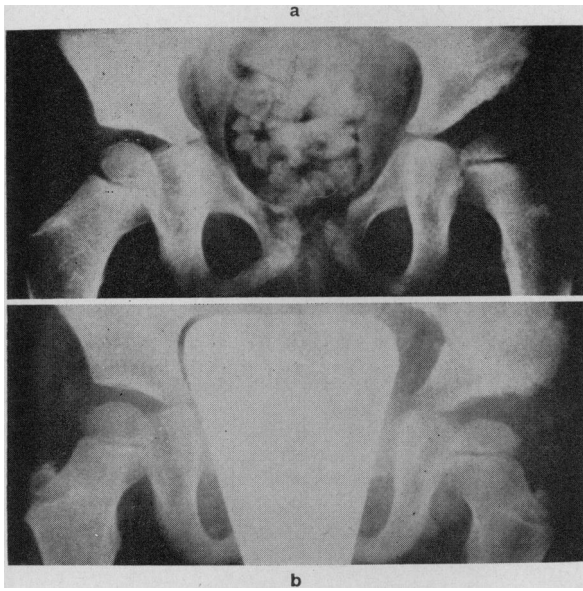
Preoperative and postoperative radiographs of the hips of a 4-year-old girl. (a) Residual acetabular dysplasia and subluxation despite one year of closed treatment; there would seem to be “sloping of the acetabular roof”. This child’s left hip was then treated by innominate osteotomy. (b) Six weeks after innominate osteotomy the left acetabulum appears comparable to the right. The only change during the six-week interval had been redirection of the entire acetabulum by the operation. Therefore, the correct interpretation of (a) is an abnormal direction of the entire acetabulum (acetabular maldirection) rather than a “sloping of the acetabular roof”.
